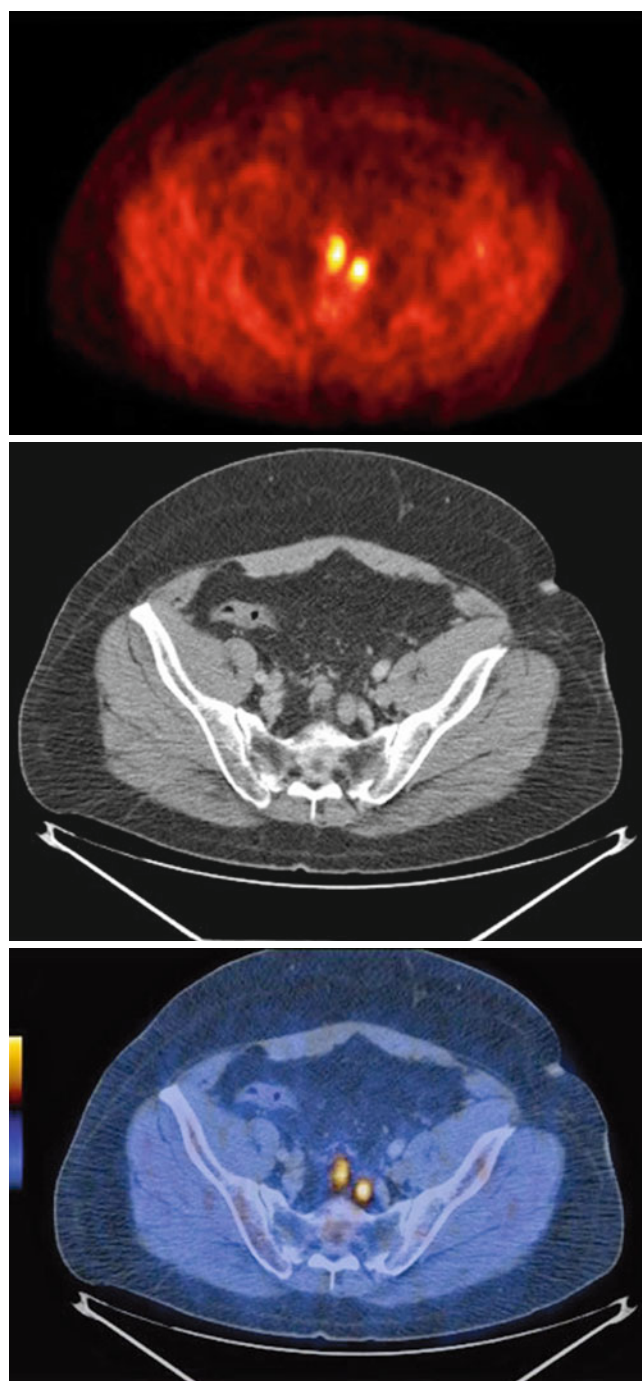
18F-fluorocholeline PET-CT in metastatic prostate cancer. From top to bottom: 18F-fluorocholeline PET, pelvis CT, and fused PET/CT images demonstrating abnormal accumulation of radiotracer in pelvic lymph node (Courtesy of Mohsen Beheshti, St. Vincent's Hospital, Linz, Austria)
